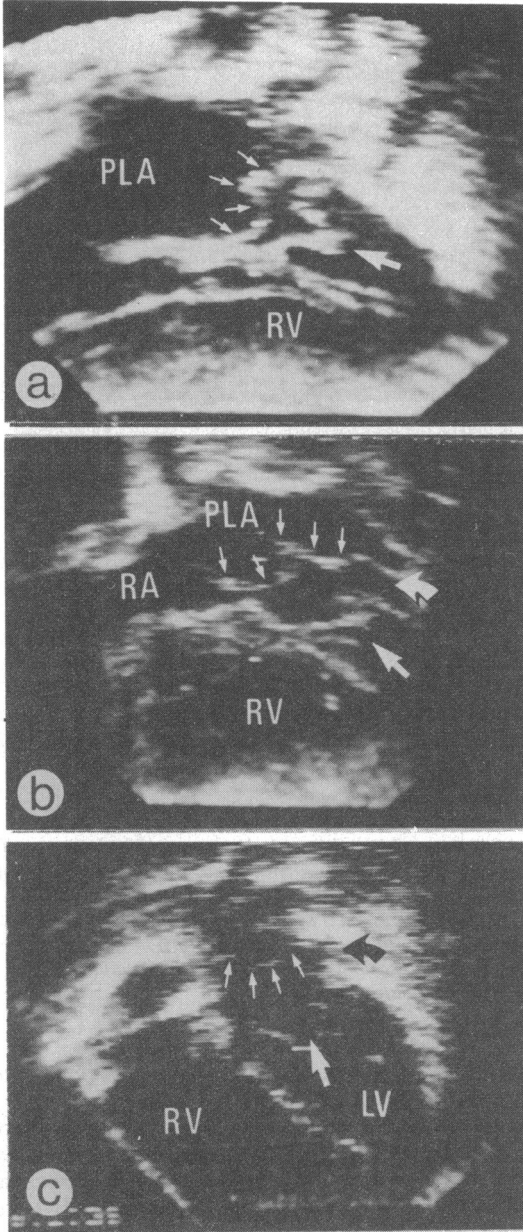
Cross sectional echocardiographic appearances in four chamber views. (a) Case 1: in a parasternal four chamber view the abnormal membrane (small arrows) within the left atrium is seen to have a double arch appearance. (b) Case 2: a parasternal four chamber view again shows a double arch appearance of the membrane (small arrows), and the left atrial appendage (curved arrow) is seen to be distal to the membrane. (c) Case 3: in the apical four chamber view the pulmonary veins can be seen entering the proximal left atrium at the top of the picture; the membrane (small arrows) has a single arch appearance, and again the left atrial appendage (dark curved arrow) is seen to be distal to the membrane. In all parts of the figure thick straight arrows point to the mitral valve. PLA, proximal left atrium; RA, right atrium; RV, right ventricle; LV, left ventricle.
